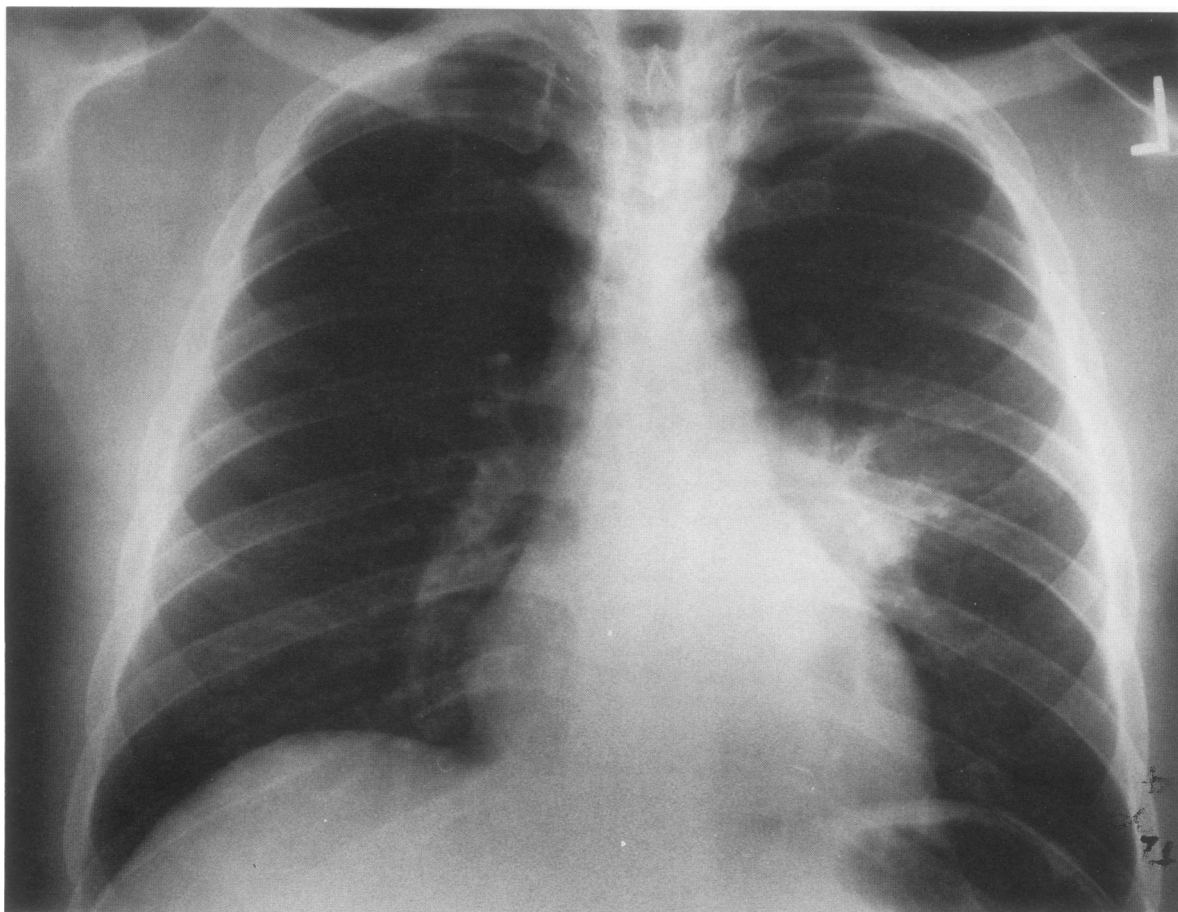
Posterior-apical chest roentgenogram of a 39-year-old, HIV-infected male with isolated pulmonary MAC infection of the superior posterior portion of the left lower lobe. Note the absence of a pleural effusion or scarring, cavitation, or hilar lymphadenopathy.
